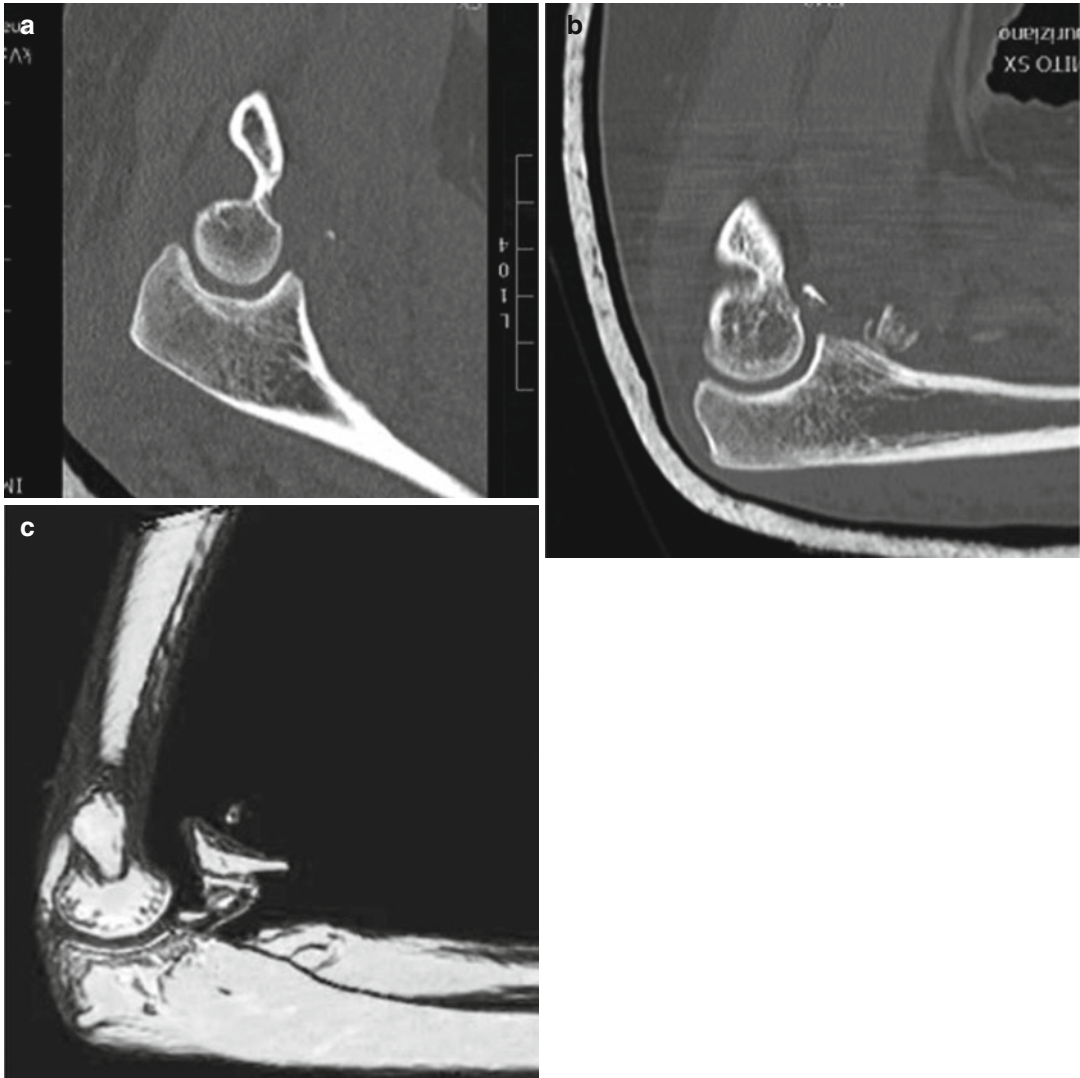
CT scan showing a type I (a), type II (b), and type III (c) fracture of the coronoid according to the Regan-Morrey classification
